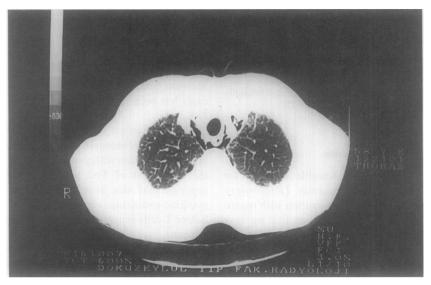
Computed tomogram taken 2 h after the rupture, showed pneumomediastinum.
